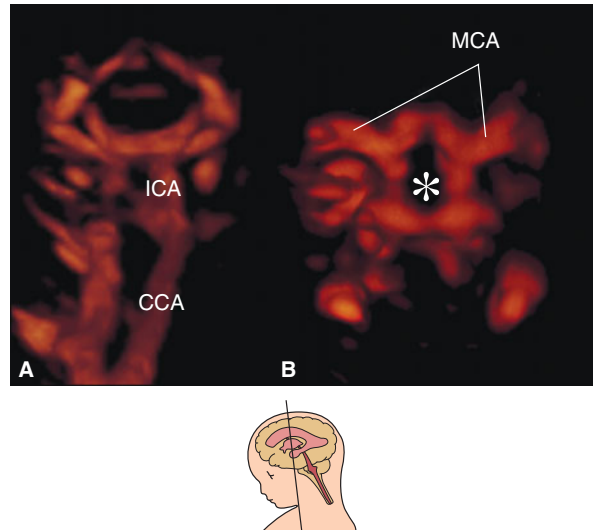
Vascular structure of normal 12 postmenstrual week brain by 3D power Doppler angiographic rendering. (A) Coronal power Doppler image of common carotid arteries (CCA), internal carotid arteries (ICA), and their branches. (B) Axial or horizontal 3D power Doppler angiographic image obtained from the parietal direction. The circle of Willis (asterisk) is clearly visualized. MCA, middle cerebral arteries.
